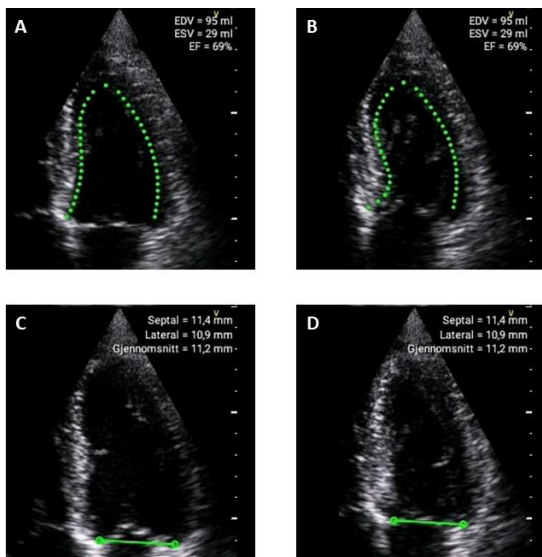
Recordings with automatic left ventricular ejection fraction and automatic mitral annular plane systolic excursion measurement overlay on hand-held ultrasound device.
